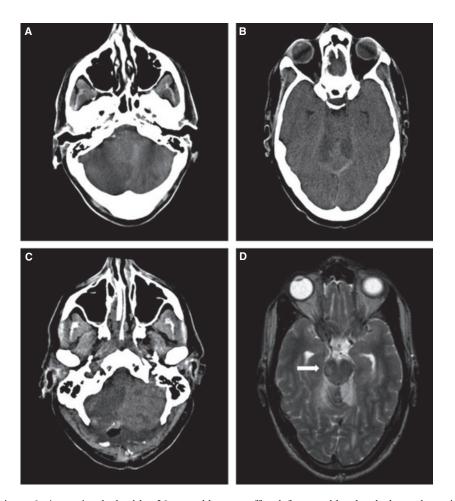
A–D: Patient 6. A previously healthy 36-year-old man suffered from sudden headache and vomiting. The morning thereafter he was found unconscious and upon arrival in the emergency room, he presented with a Glasgow coma scale score of 5. Brain CT scan showed a space-occupying bilateral cerebellar infarction with marked mass effect. The infarct was surgically decompressed immediately following the arrival in our unit. A post-operative magnetic resonance imaging (MRI) showed dissection of the right vertebral artery at the level of C1 and also a brain stem infarct. Following neurointensive care, the patient was extubated, and at discharge he was RLS:2, obeying verbal commands but was unable to speak. At the last long-term follow-up, the patient was mRS:4 with marked ataxia as the predominant problem. (A) Preoperative CT scan of the brain. Bilateral cerebellar infarction in the area of the middle and lateral branch of the posterior inferior cerebellar artery (PICA) on the right side and in the middle branch of PICA on the left side. Complete obliteration of the 4th ventricle with Grade III compression. (B) Preoperative brain CT scan on the same patient. Bilateral cerebellar infarction in the area of the middle branches of the superior cerebellar artery. (C) Post-operative brain CT scan showing decreased compression of the posterior fossa contents. (D) Post-operative T2-weighted brain MRI scan demonstrating a brain stem infarct (arrow). RLS, reaction level scale; mRS, modified Rankin scale.
